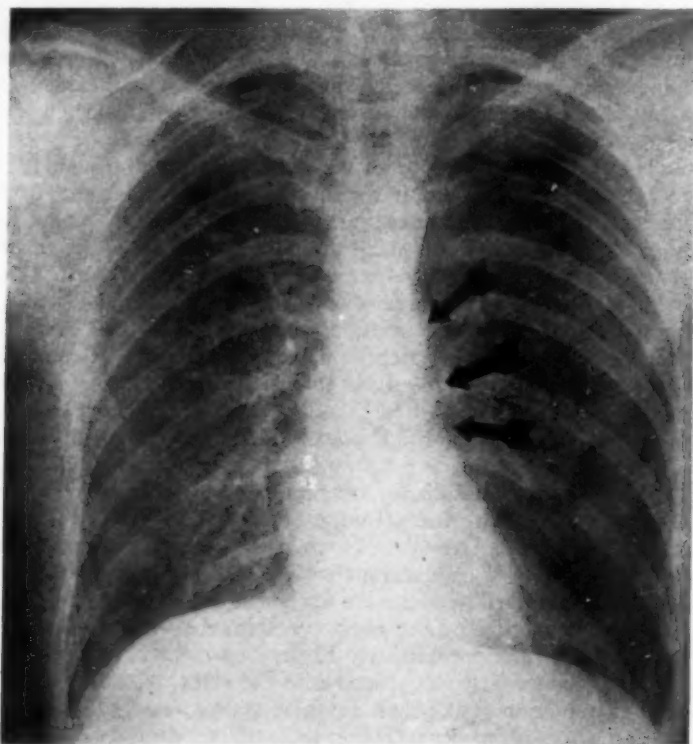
Roentgenogram of the chest showing pneumothorax on the left side and an area of lessened density due to mediastinal emphysema.
